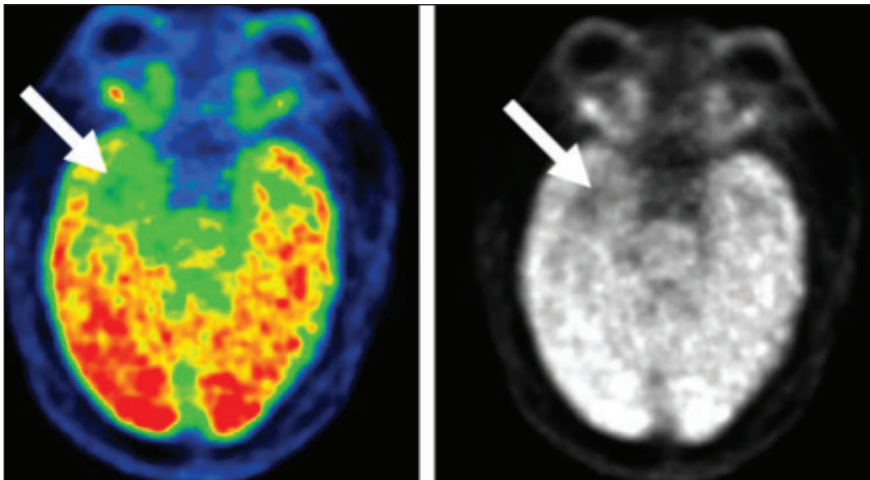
FDG-PET/CT is demonstrating hypometabolism in the right mesial (arrow) temporal structures in patients with right-sided MTS.
